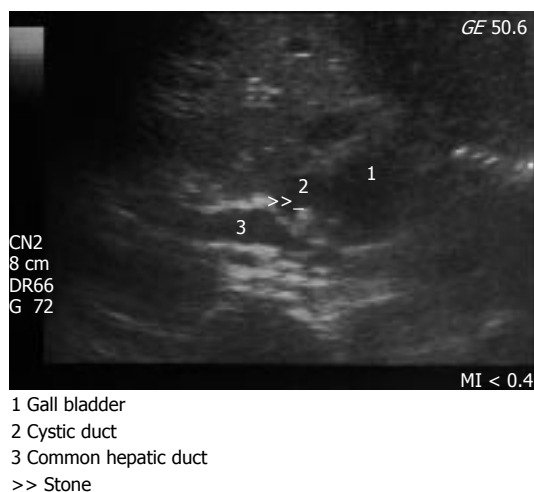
Ultrasound showing a stone compressing the common hepatic duct.
